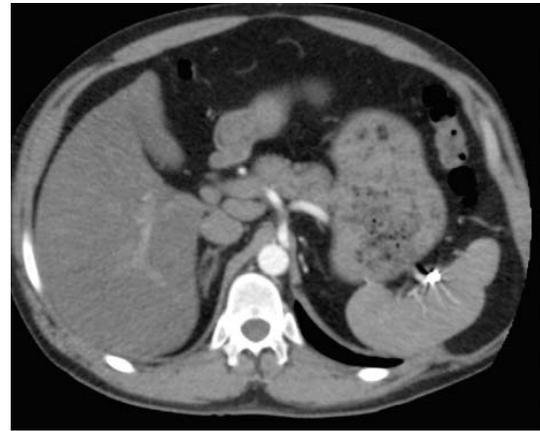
CT scan of the abdomen 2 years following the ATV accident demonstrates no evidence of residual pseudoaneurysm or arteriovenous fistula, patent flow in the main splenic artery, and homogeneous enhancement of the splenic parenchyma. There is a focal cortical scar in the area of splenic injury and embolization.
